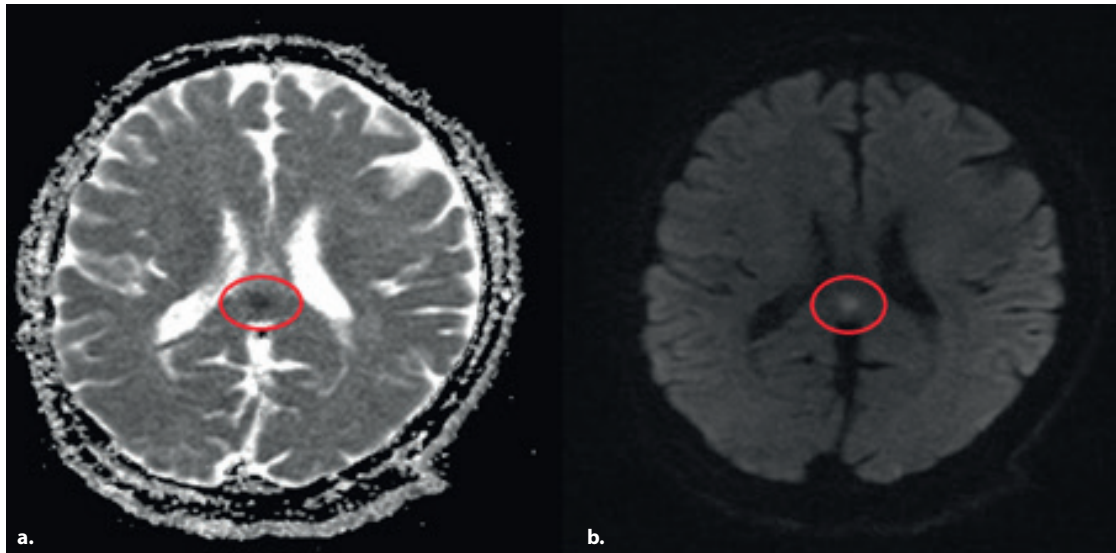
Cranial diffusion MRI, an acute diffusion restriction 5mm in diameter was observed in splenium CC.
